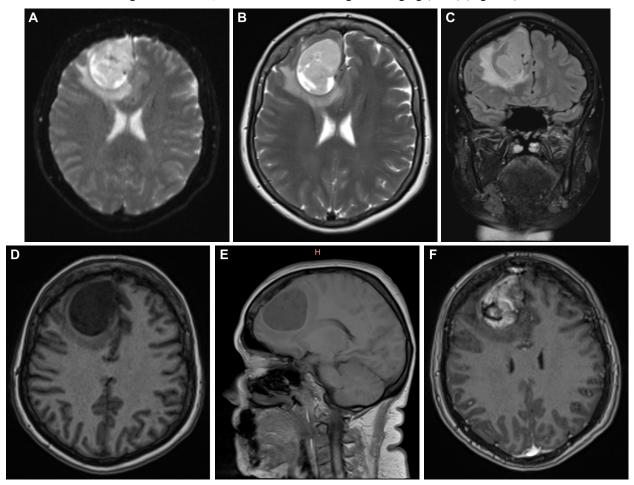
MRI analysis: (A) Axial diffusion; (B) Axial T2; (C) Coronal T2; (D) Axial T1; (E) Sagittal T1; (F) Axial T1 with contrast enhancement.
